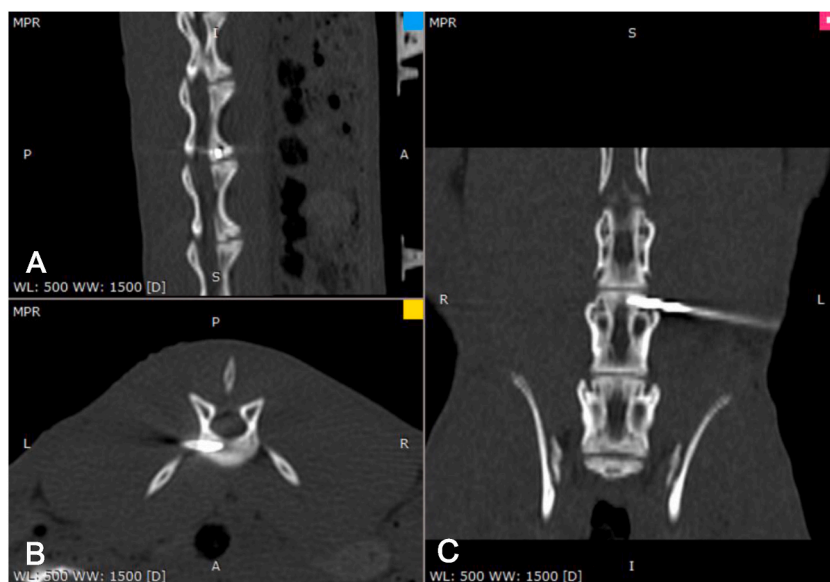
The process of tumor implantation under CT guidance. A: sagittal view; B: axial view; C: coronal view, showing that the puncture needle enters the medullary cavity at the front end of the L5 vertebral body.
